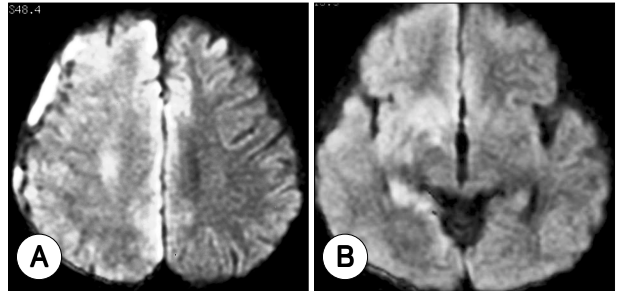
Diffusion magnetic resonance imaging on 12th day. A : High signal intensity of right internal carotid arterial territory. B : High signal intensity of right basal ganglia.
